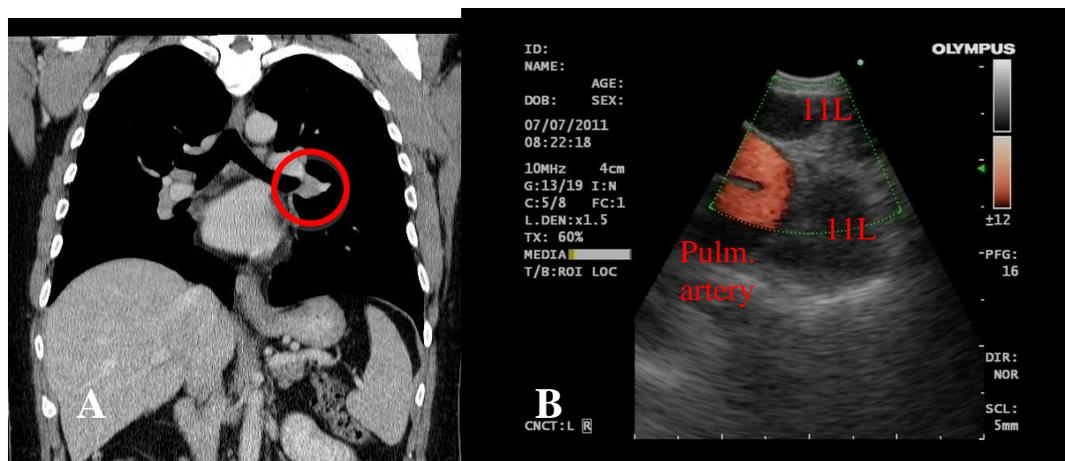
Lymph node in position 11L, adjacent to branching left pulmonary artery. A – CT scan, B – EBUS with Color Power Doppler.
